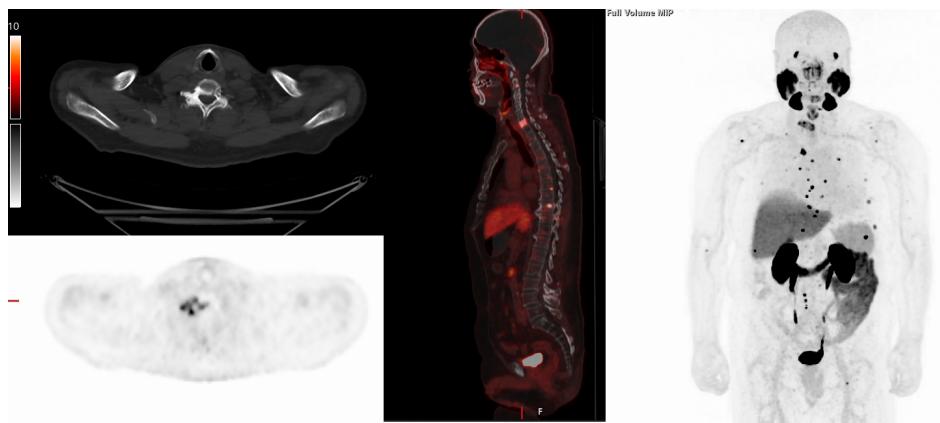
^{18}F -DCFPyl PET/CT in a patient with metastatic prostate carcinoma and multifocal osseous lesions.
